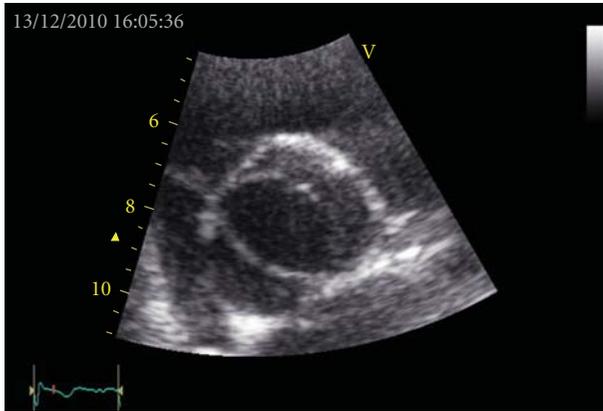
Echocardiographic image of a bicuspid aortic valve.
